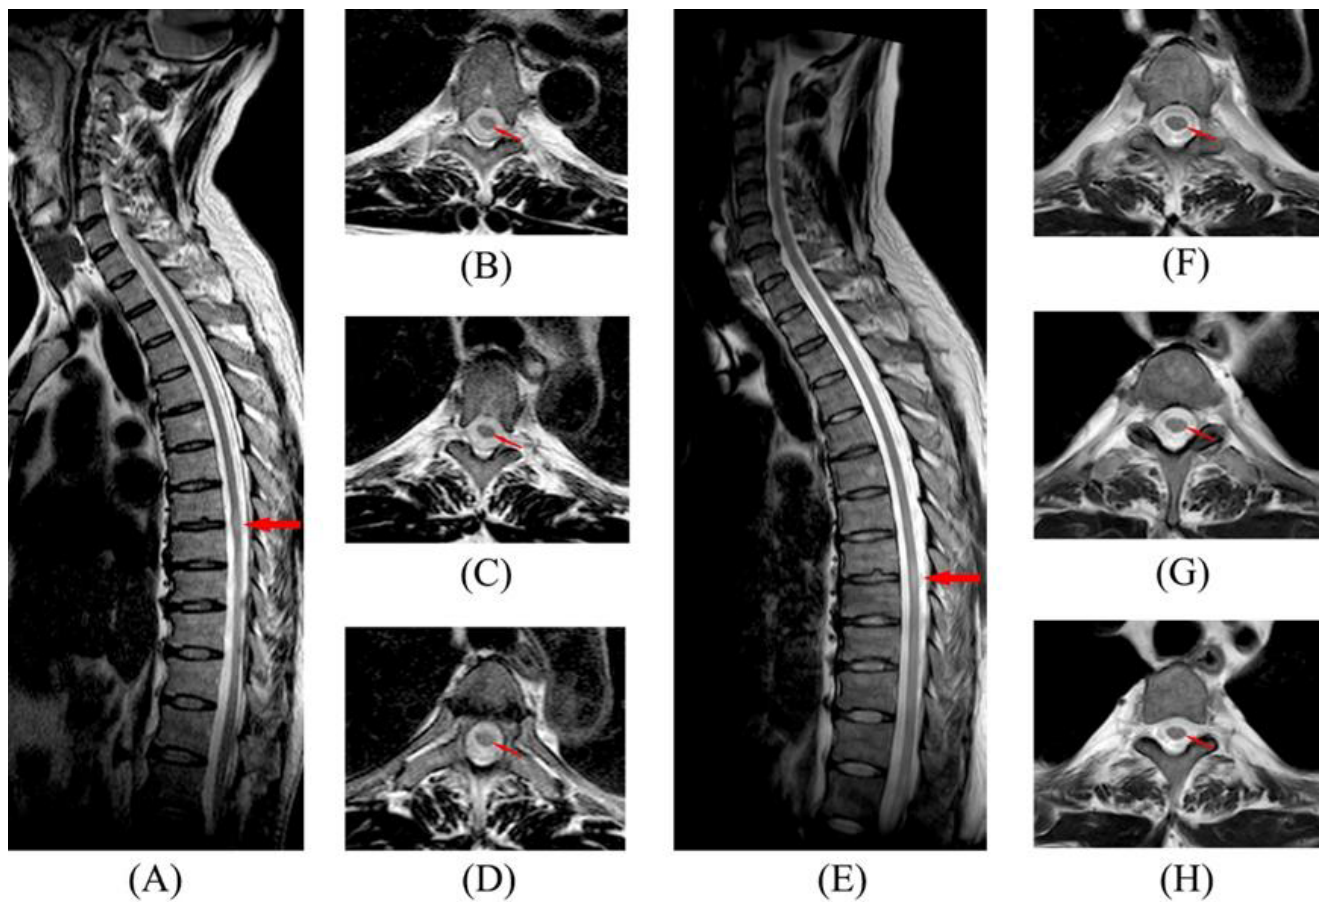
The MRI scanning was performed utilizing 1.5T Siemens MR imaging systems. A-D were finished in July 2017, while the E-H in September 2018. T2WI presented hyperintensities in T8-9 level thoracic cord, accompanied by spinal cord swelling (A). There were patchy area of hyperintensity within the transverse section of spinal cord (B-D). The hyperintensity were remaining detected in T8-9 level thoracic cord, while the spinal cord swelling disappeared (E). Patchy hyperintensity could be detected in the spinal cord (F-H).
